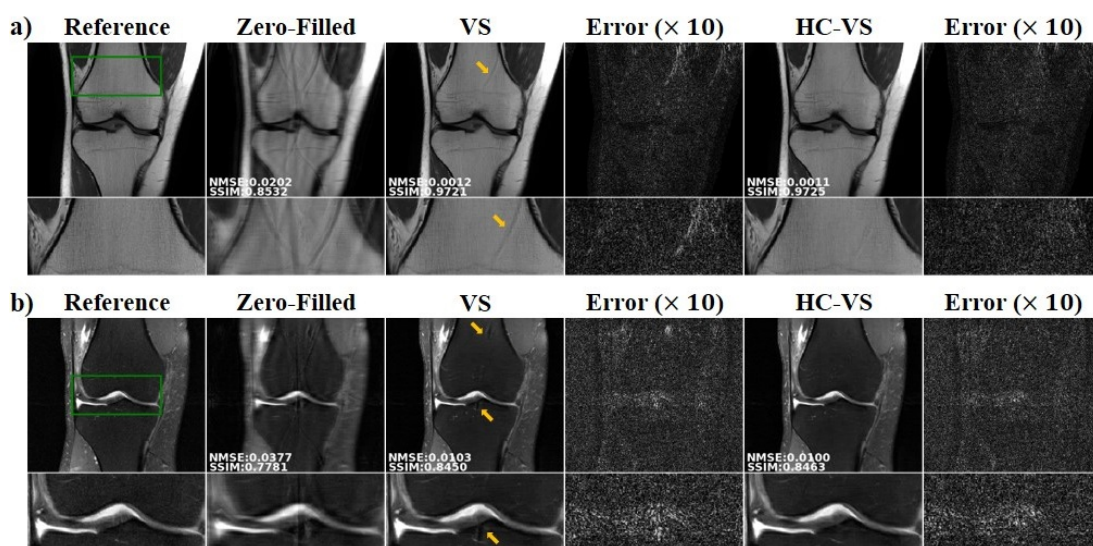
Example slices from (a) the Coronal PD and (b) Coronal PD-FS datasets with 4-fold uniform undersampling, reconstructed with DL-MRI reconstruction based on the conventional VS and the proposed HC-VS unrolling, as well as error images ($\times 10$), with the green rectangle showing the zoom-up area. The reconstructions from the history-cognizant unrolling approach, HC-VS suppresses the residual aliasing visible in the conventional VS unrolling, as marked by the arrow. Improvements are also observed in the quantitative metrics.
